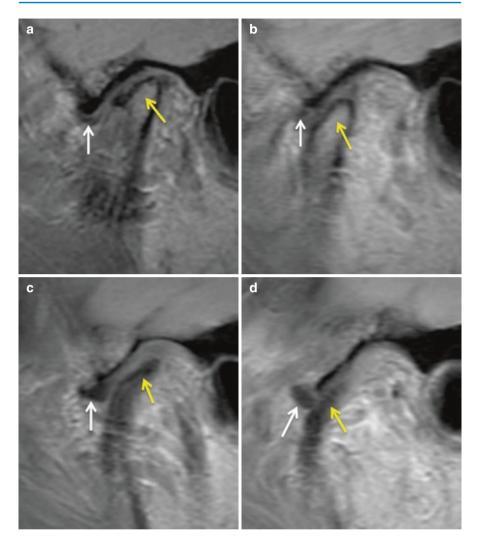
Case 1: presurgery TMJ MRI sagittal images. (a) Right TMJ closed and (b) open views show severe arthritis of condyle (yellow arrow) and anteriorly displaced disc (white arrow) severely degenerated, nonreducing, and non-salvageable. (c) Left TMJ closed and (d) open views show severe destruction of the condyle (yellow arrow) with the articular disc (white arrow) severely degenerated, nonreducing, and non-salvageable
